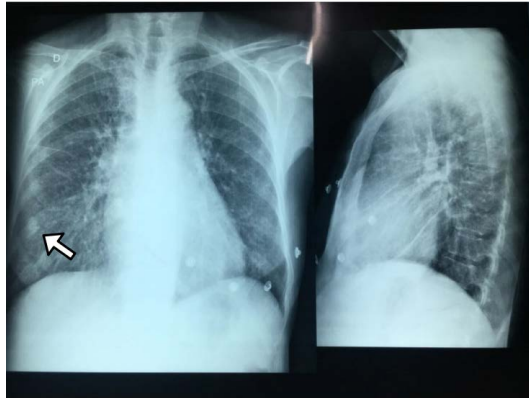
Chest X-ray PA and Profile: Diffuse interstitial involvement with a reticulonodular pattern, increased cardiothoracic index, mediastinal widening and consolidated fracture of the right eighth costal arch (arrow).
